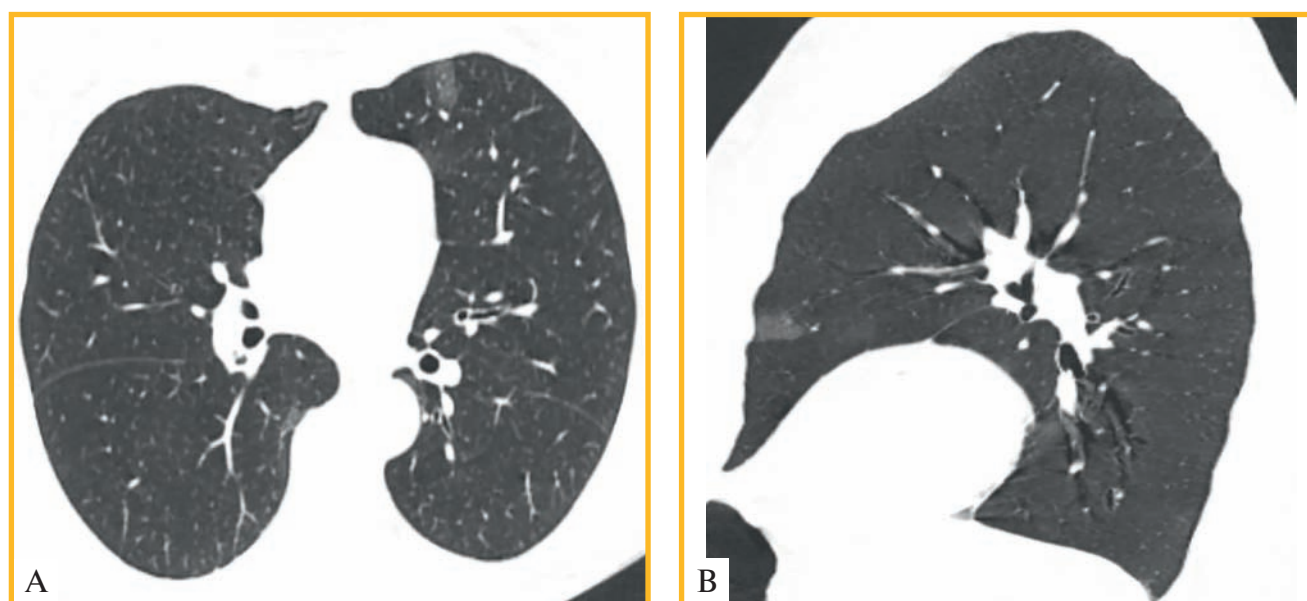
Multispiral computed tomography of the chest (1 mm slices) on the 2nd day of clinical onset of COVID-19 pneumonia: A, Axial slice. A ground glass opacity in the left lingular segment; B, Sagittal reconstruction in MinIP mode provides clearer visualization of the findings
